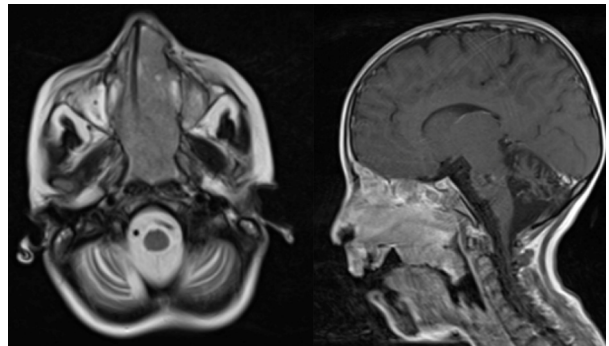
Pre-treatment MRI image of the lesion.
